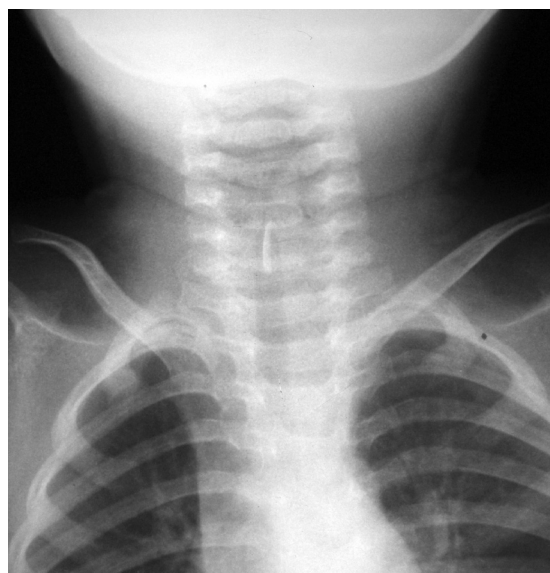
Frontal radiograph shows a radiopaque subglottic foreign body.
